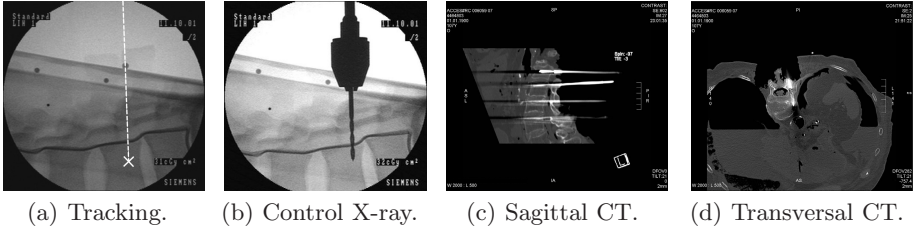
Evaluation of the developed system using a control X-ray I_x^{90} and postinterventional CT data
